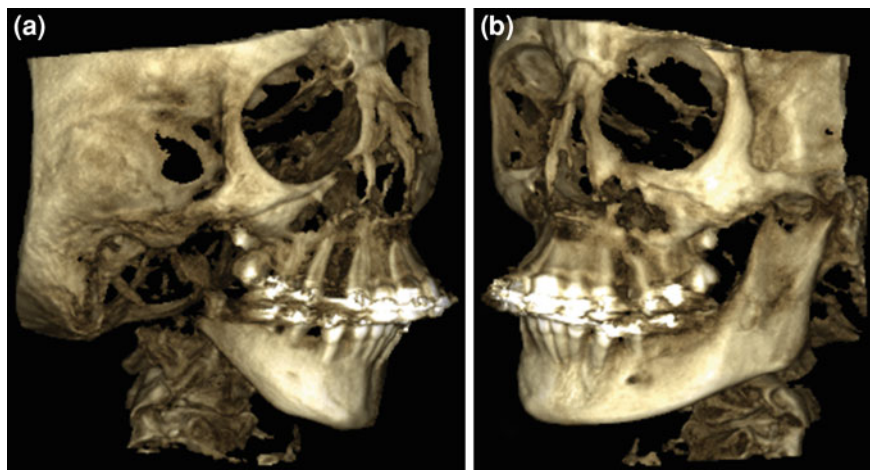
CBCT 3D reconstruction of right (a) and left (b) hemifacial shows the evident mandibular asymmetry
